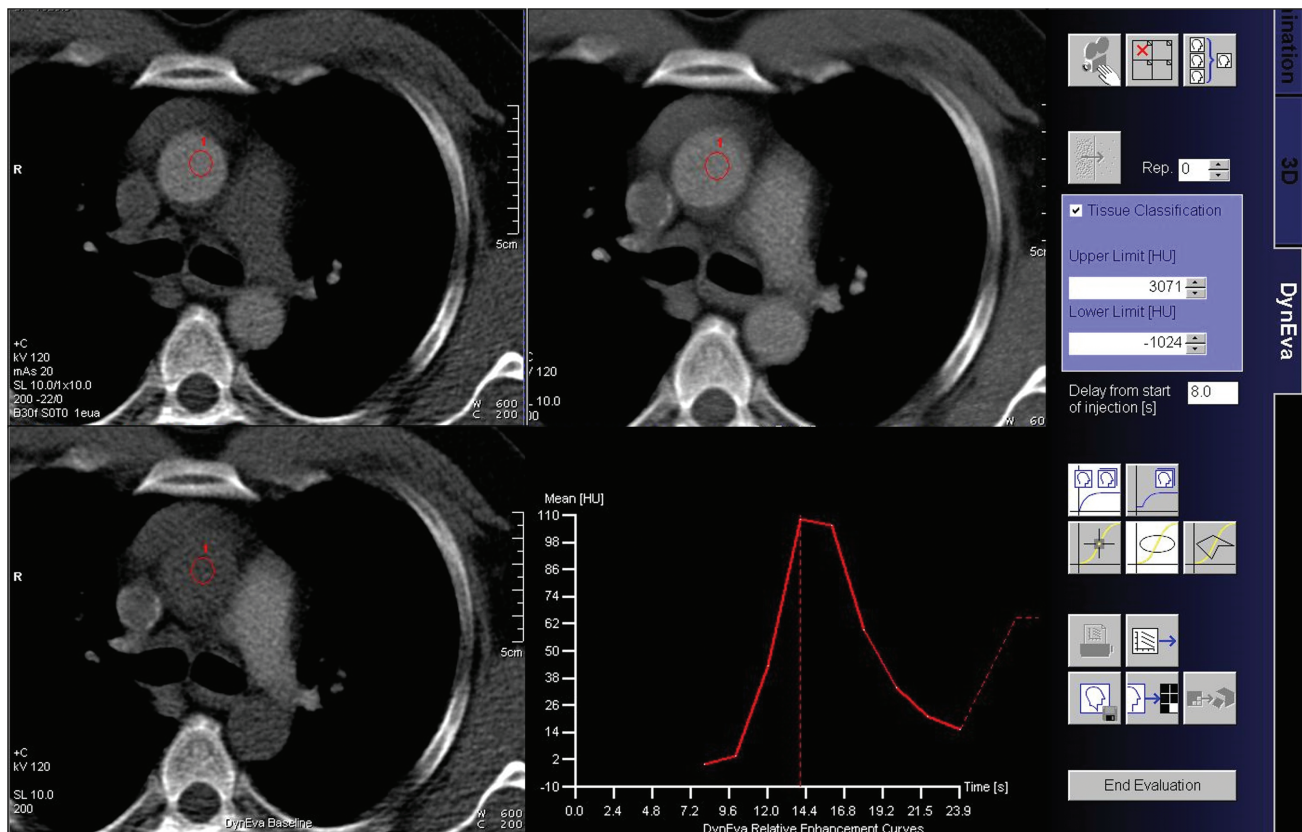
Test-bolus technique. For computed tomography coronary angiography (CTCA), the region of interest is placed in the ascending aorta and low-dose scans are acquired following injection of a test dose of contrast. The time-density curve is plotted for the bolus and the scan delay time is automatically displayed based on software calculations.
